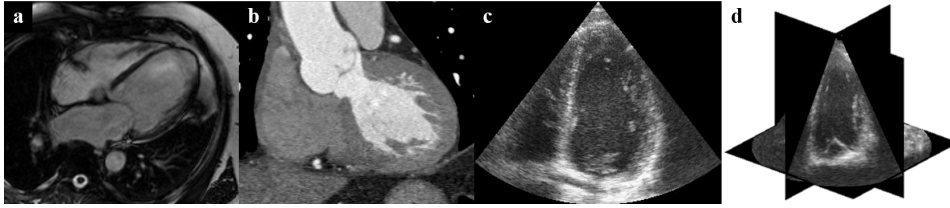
Examples of different cardiac imaging modalities: cMRI (a), CT (b), 2DE (c) and RT3DE (d). CT image courtesy of Walter Coudyzer, Department of Radiology, UZ Leuven, Belgium.
